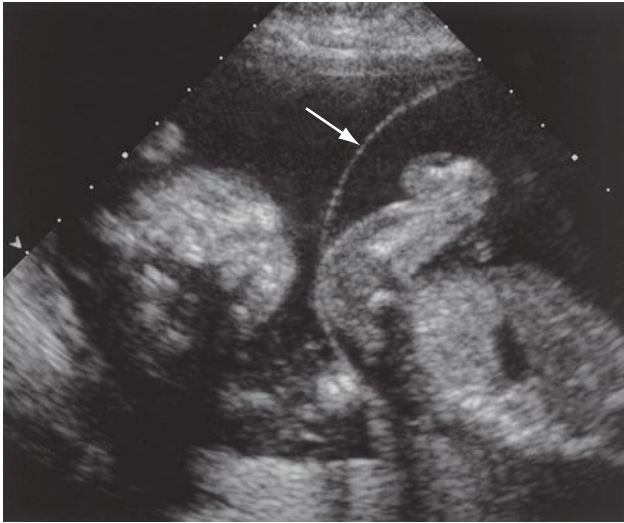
Sonogram from a patient with a diamniotic dichorionic twin pregnancy. Subjective evaluation revealed normal amniotic fluid in each gestational sac on either side of the amniotic membrane (*arrow*).
